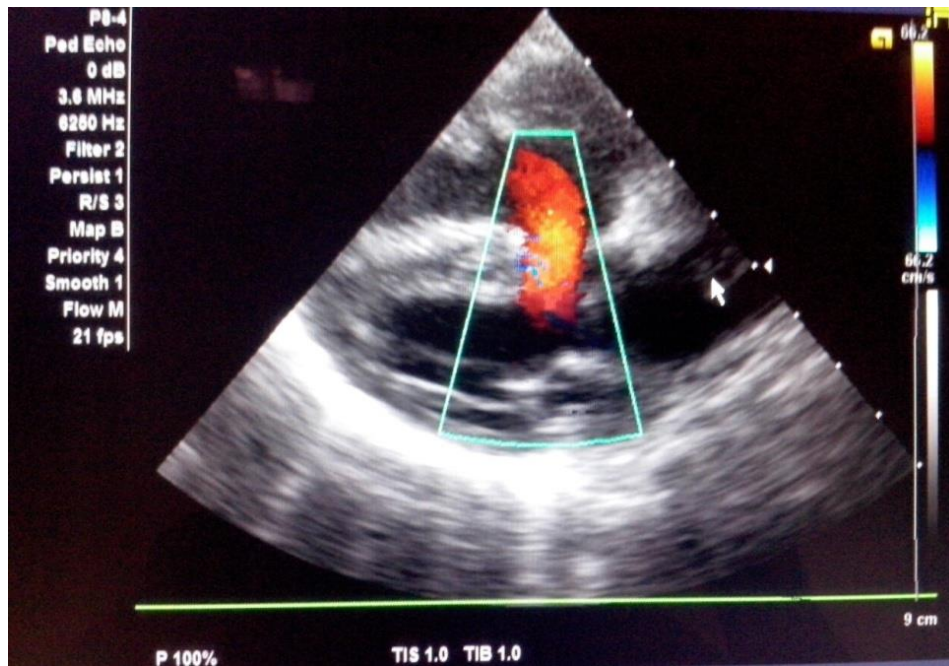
Echocardiography showing ventricular septal defect (VSD)
